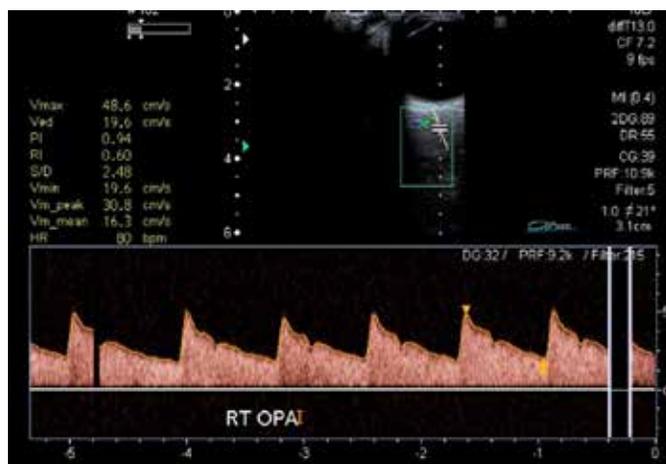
Color doppler image of vessel and corresponding waveform of ophthalmic artery
